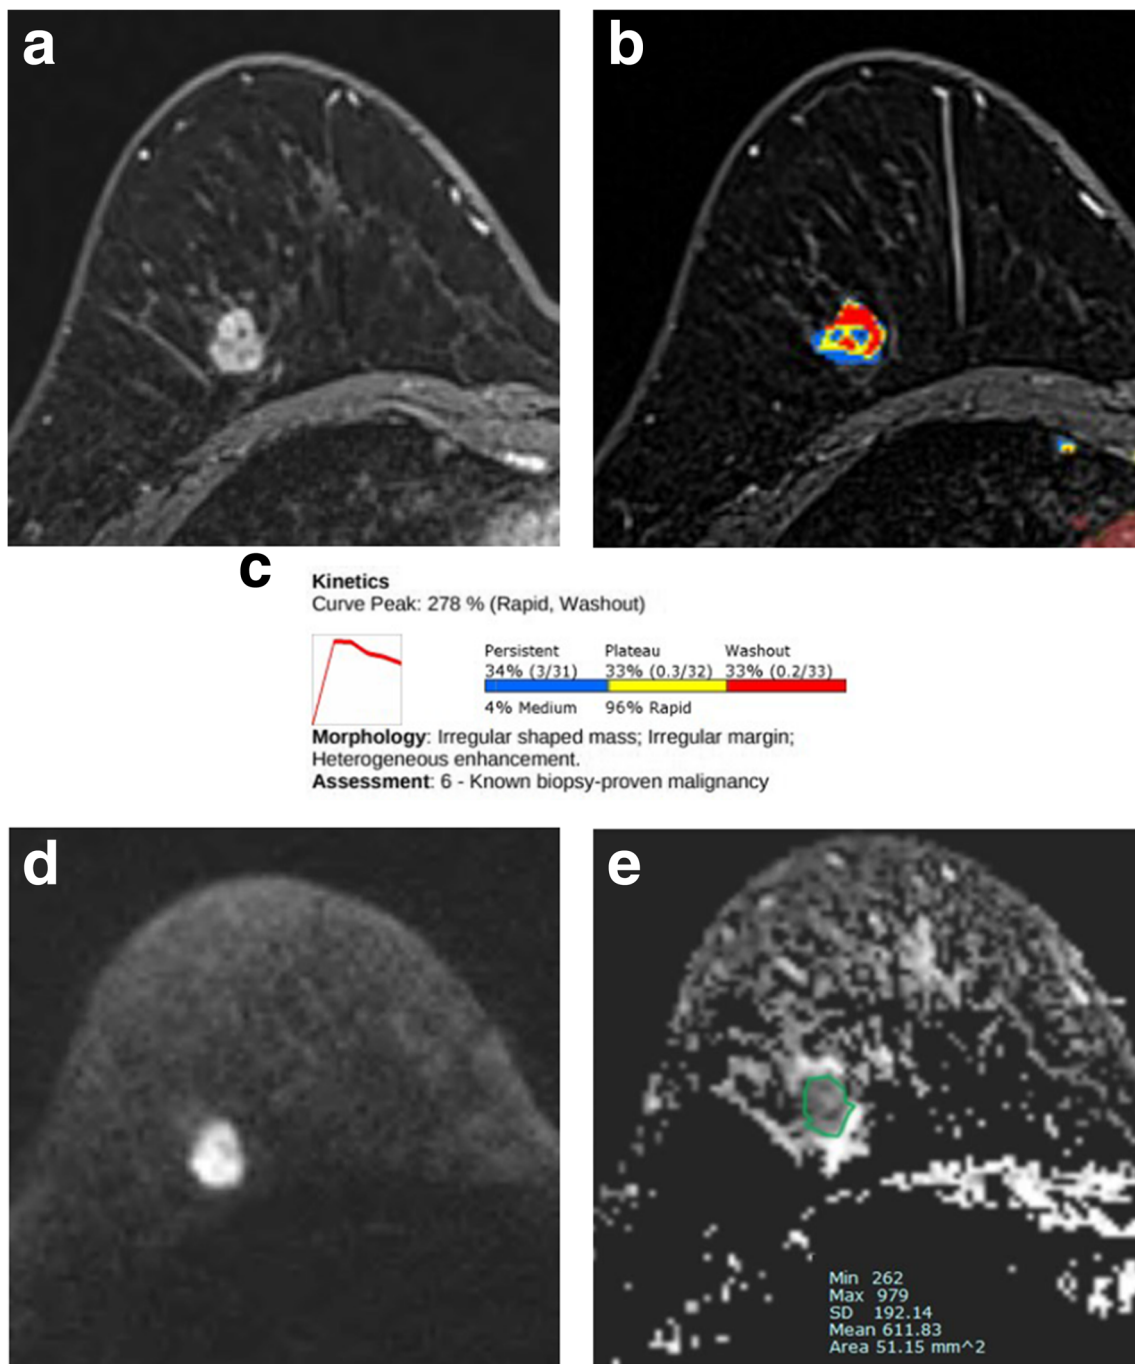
Preoperative breast magnetic resonance images of the right breast in 52-year-old woman with invasive ductal carcinoma. a Axial contrast-enhanced T1-weighted images shows an irregular heterogeneously enhancing mass in the right breast. b A computer-assisted diagnosis (CAD) color overlay map shows heterogeneous kinetics with the tumor. Red, yellow, and blue areas indicate washout, plateau, and persistent enhancement patterns, respectively. c The auto-portfolio from the CAD system shows the delayed enhancement profiles of the breast cancer. The kinetic heterogeneity value was 0.99. d Axial diffusion-weighted imaging
